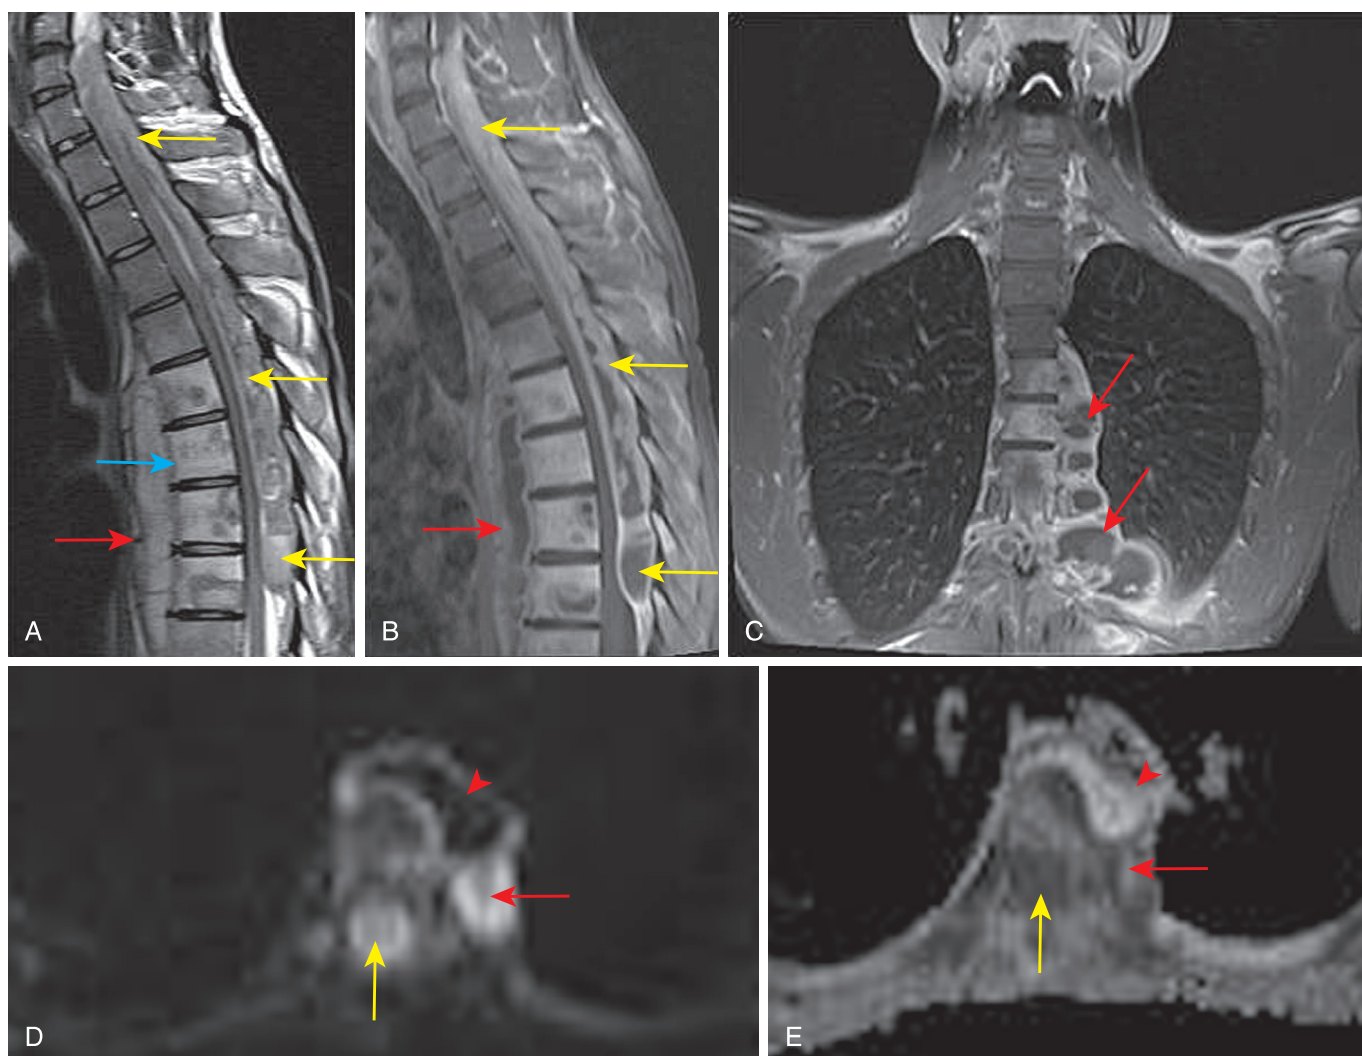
Tuberculous spondylitis with epidural and paraspinal abscesses. Sagittal T2 image (A) shows abnormal marrow signal from T4 to T9 (blue arrow) with abnormal fluid collections in the epidural (yellow arrows) and prevertebral (red arrows) spaces. These collections are better seen on postcontrast sagittal (B) and coronal (C) images. Note the sparing of the intervertebral discs. DWI (D) shows areas of hypointensity and hyperintensity with corresponding high and low ADC values (E). The collection with high ADC value (red arrowhead in D and E) is a “cold abscess.” (From Moritani T, Kim J, Capizzano AA, et al. Pyogenic and non-pyogenic spinal infections: emphasis on diffusion-weighted imaging for the detection of abscesses and pus collections. *Br J Radiol.* 2014;87[1041]:20140011.)
